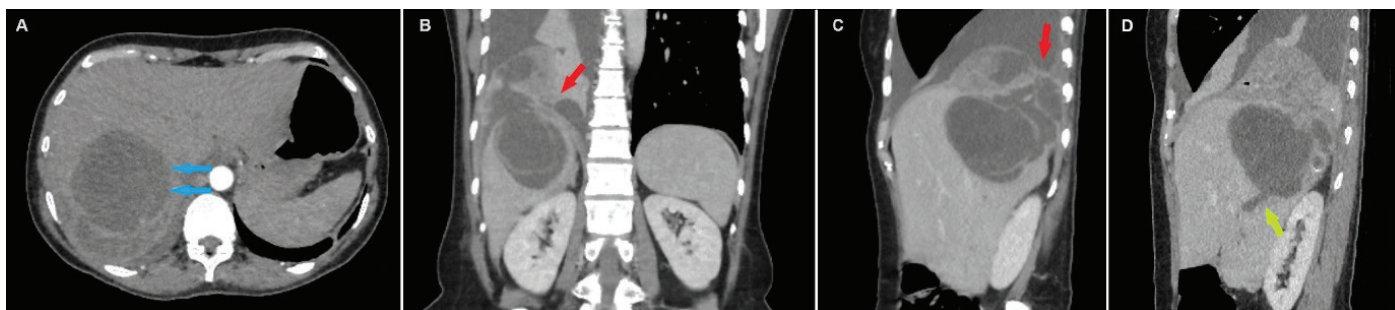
Axial section (A) contrast-enhanced computed tomography CT, shows a cystic lesion with a subdiaphragmatic location, septate internal structure, and loss of wall tension and separated membranes observed in liver segments VII and VIII (blue arrows). On coronal and sagittal sections (B, C), the detected cyst had passed the diaphragm and extended to the right hemithorax (red arrows). The sagittal section (D) is an enlarged bile duct adjacent to the identified cyst, and its appearance suggests cystobiliary communication (green arrow).
